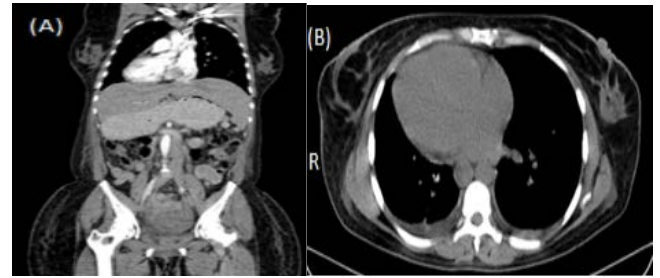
(a) Thoracoabdominal CT in coronal view, showing inversion of the position of the thoracic and abdominal organs. (b) Chest CT showing dextrocardia.
